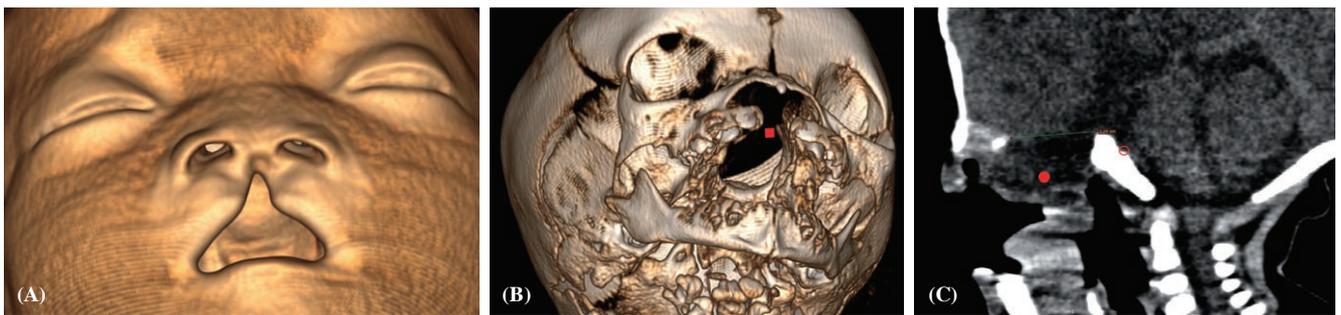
Volumetric rendered images showing the (A) soft tissue defect in the upper lip and associated (B) fusion abnormality of the hard palate and maxillary alveolus (red solid square). (C) Sagittal reconstruction of the facial CT showing the sphenothmoidal defect. Radiographically, the clinically apparent nasal mass is seen as a sac containing herniated intracranial contents (red solid circle). Note the absent sella turcica with non-visualization of the pituitary gland (red hollow circle).
